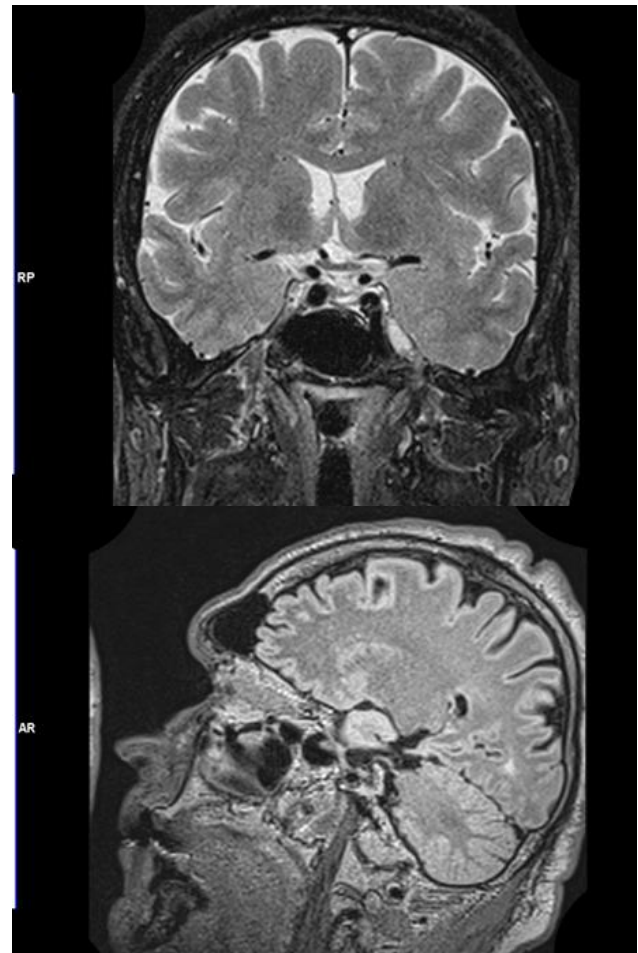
Pituitary magnetic resonance imagery one year after the diagnosis of acromegaly was done and pituitary surgery was practiced. A tumour is identified of 0.5 by 0.7 by 0.9 cm
